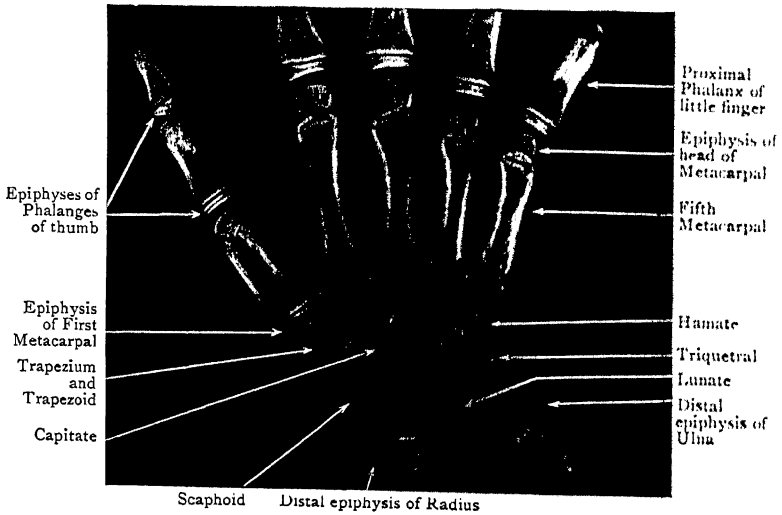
Radiograph of Wrist and Palm of girl aged 7.
